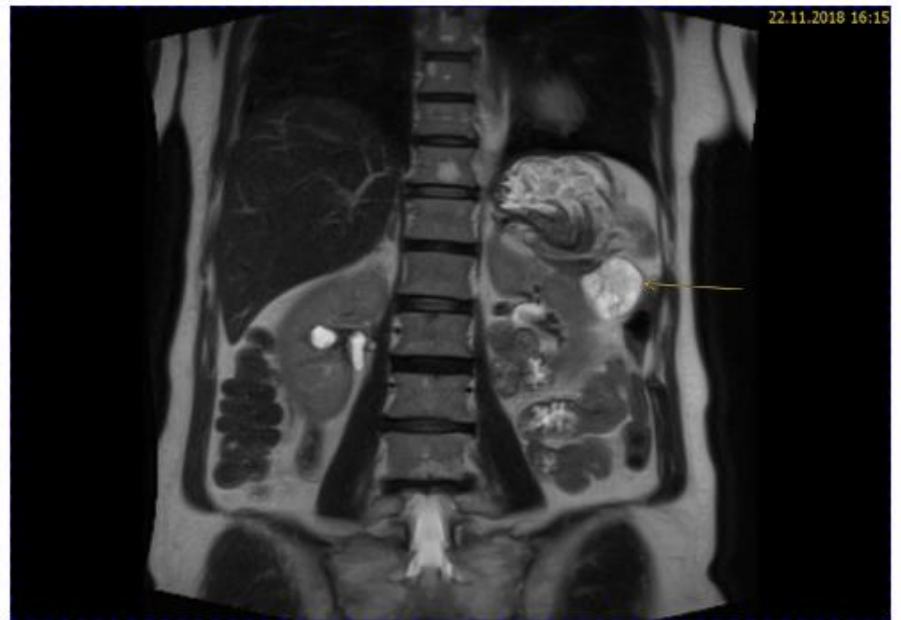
MRI with yellow arrow showing large exophytic mass originating from the pancreas tail (33×47×38 mm).
